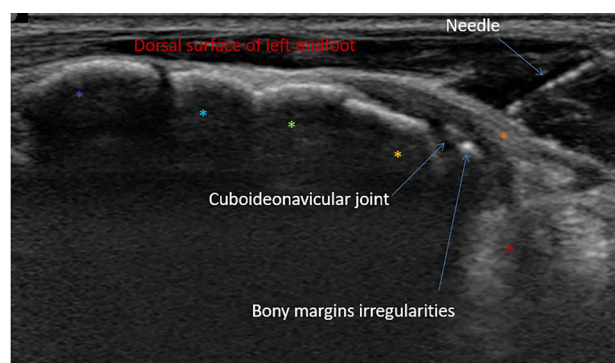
Short axis view ultrasound image of the left midfoot. A corticoid injection is performed at the site of the cubonavicular coalition. Bony margin irregularities of cuboideonavicular joint are evident. Dorsal Cubonavicular ligament (orange asterisk), Navicular (yellow asterisk), Cuboid (red asterisk), Medial Cuneiform (purple asterisk), Intermediate cuneiform (blue asterisk), Lateral cuneiform (green asterisk).
